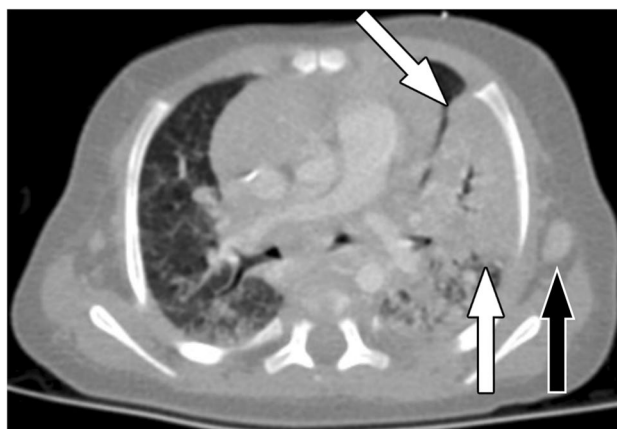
2-month-old boy with acute fungal infection due to coccidioidomycosis. Axial chest CT image with IV contrast material shows left upper lobe consolidation (white arrows) with air bronchograms, mimicking bacterial community-acquired pneumonia, as well as an enlarged left axillary lymph node (black arrow)
